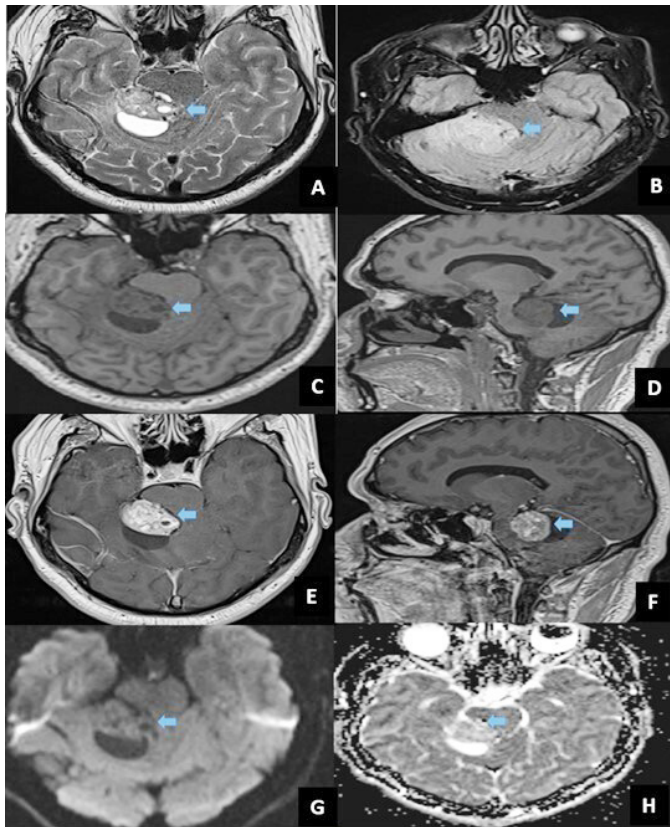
A. In the axial plane, T2-weighted sequence has cystic components in iso-hyperintense heterogeneous, creating a significant compression effect from the right posterolateral, obliterating the 4th ventricle close to total. B. Signal changes consistent with hyperintense edema in the hyperintense heterogeneous surrounding parenchyma in the FLAIR sequence in the axial plane C and D. T1-weighted sequence iso-hypointense heterogeneous in axial and sagittal planes, respectively. E and F. There is an intraaxial mass lesion with heterogeneous intense contrast enhancement in T1-weighted sequence with contrast in the axial and sagittal planes, respectively. G. No diffusion restriction in Diffusion-weighted and ADC sequences, respectively.
